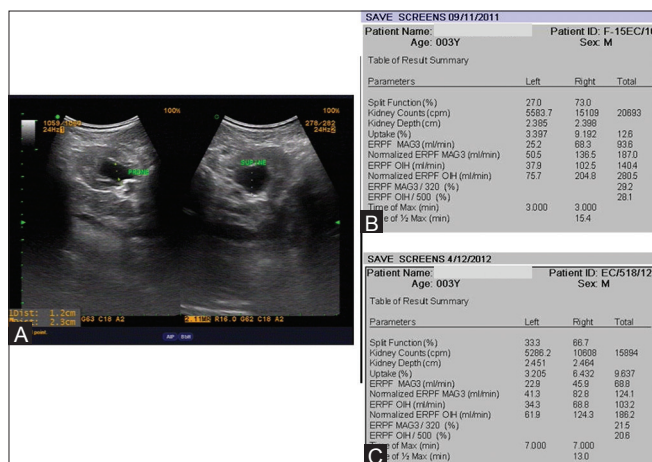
(A-C): (A) Post-pyeloplasty ultrasound showing APD of left kidney in supine 23 mm and in prone position 12 mm (B) Pre-pyeloplasty renogram showing left kidney having 23% differential function (C) Post-pyeloplasty renogram showing 33.3% of left kidney – improved renal function suggesting a successful pyeloplasty
